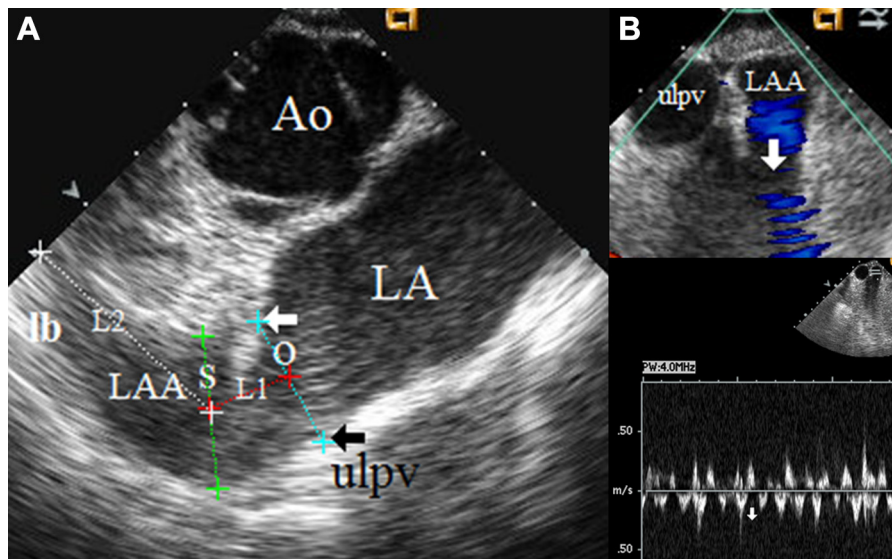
Intracardiac Echocardiographic Image of the LAA and its Emptying Flow
